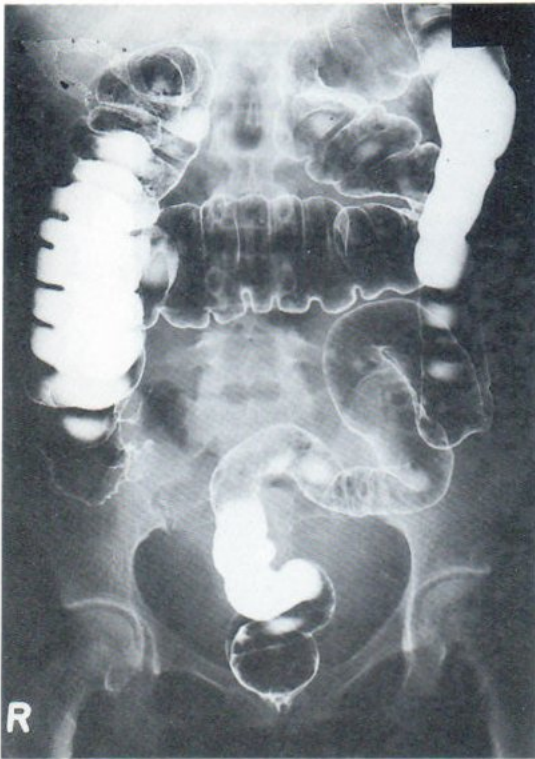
Barium enema AP radiograph. Extrinsic lesion at the caecal pole distorts the outline. The rest of the colon is normal.
